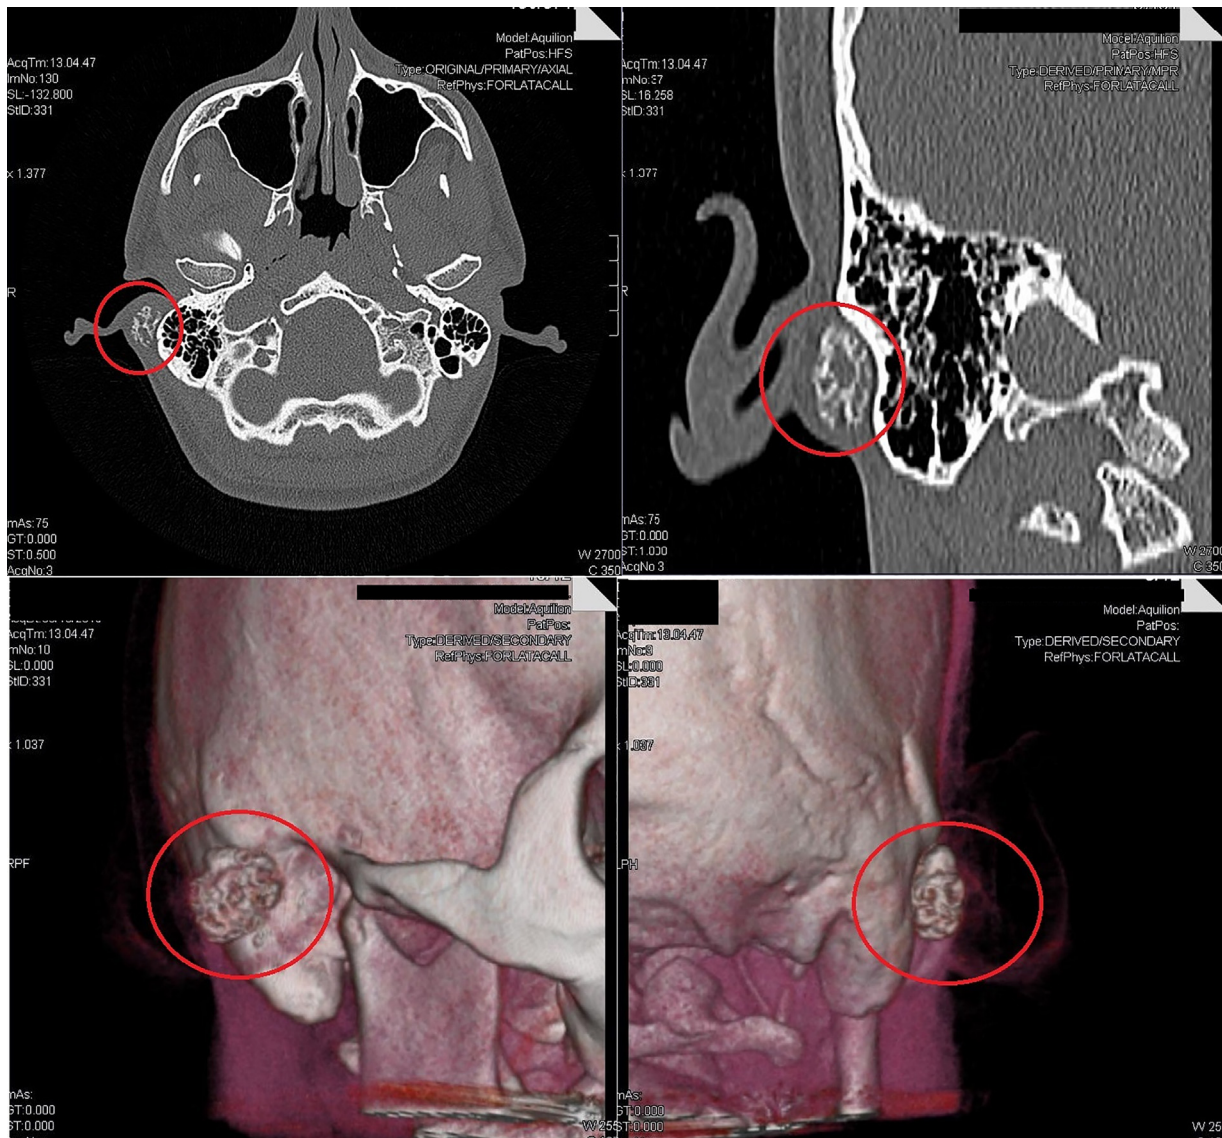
CT ear scan with coronal, sagittal and 3D reconstructions, with red circles pointing the location and the extension of the neoformation.
